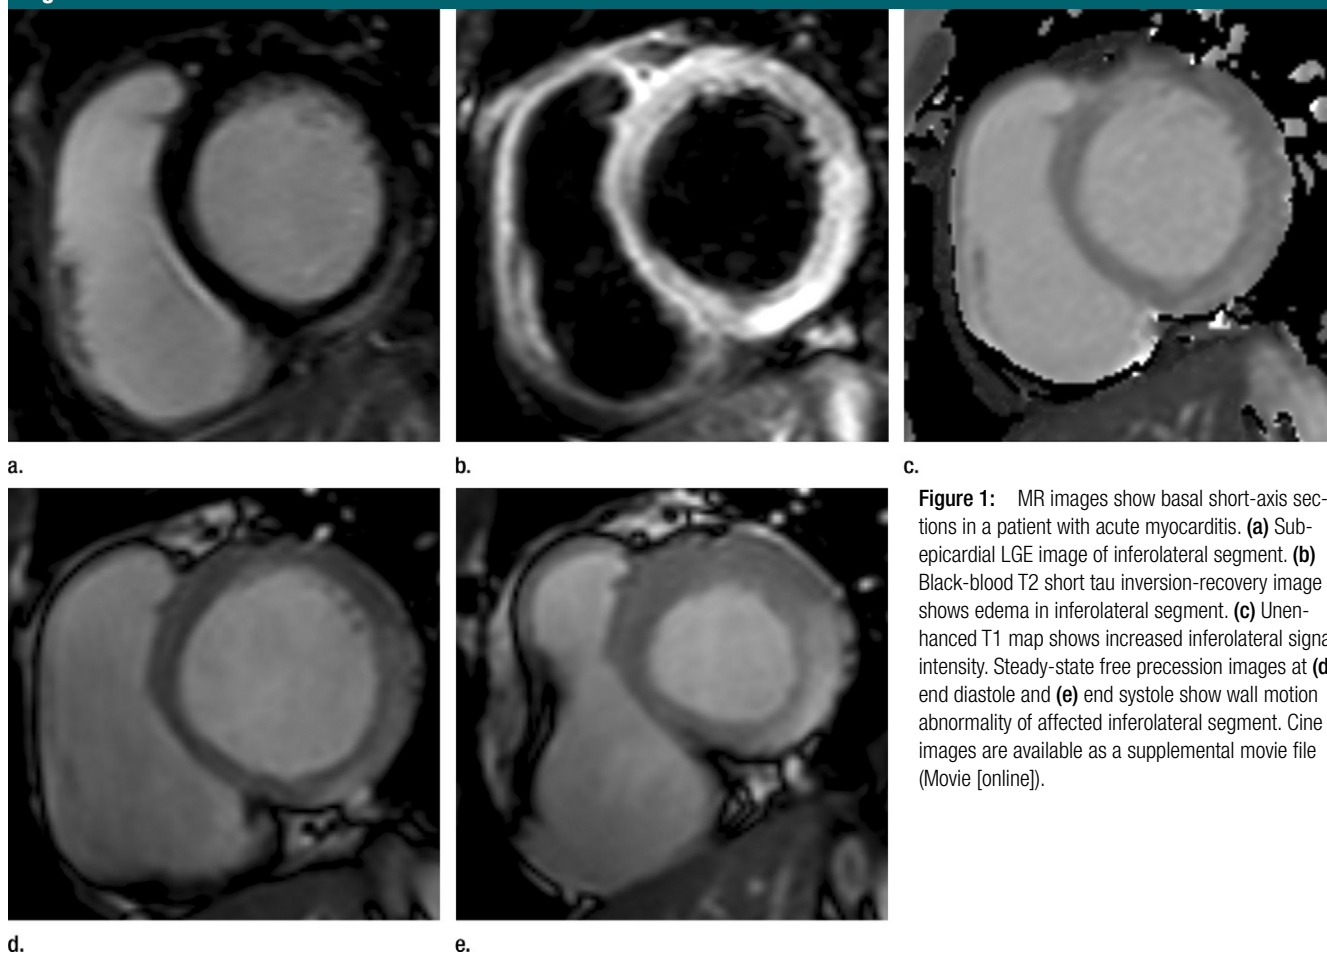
MR images show basal short-axis sections in a patient with acute myocarditis. (a) Sub-epicardial LGE image of inferolateral segment. (b) Black-blood T2 short tau inversion-recovery image shows edema in inferolateral segment. (c) Unenhanced T1 map shows increased inferolateral signal intensity. Steady-state free precession images at (d) end diastole and (e) end systole show wall motion abnormality of affected inferolateral segment. Cine images are available as a supplemental movie file (Movie [online]).
